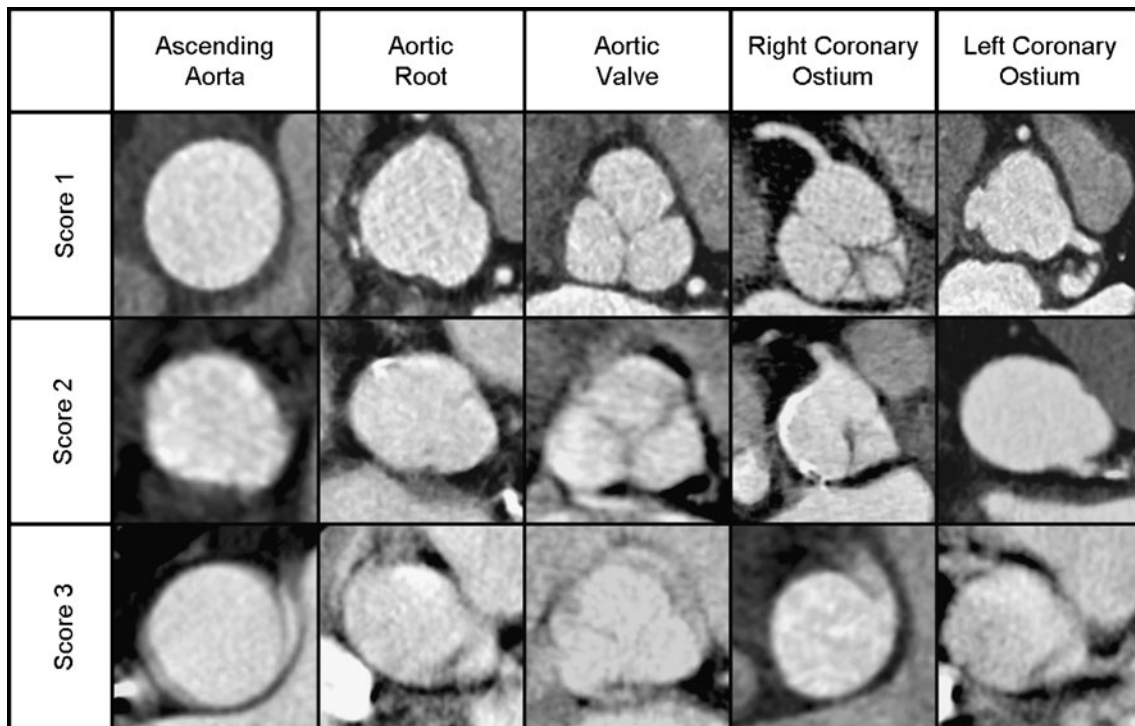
CT examples for the assessment of image quality scores of the ascending aorta, the aortic root, the aortic valve as well as the right and left coronary ostium. *Score 1* = excellent image quality; *Score 2* = moderate image quality; *Score 3* = non-diagnostic image quality
